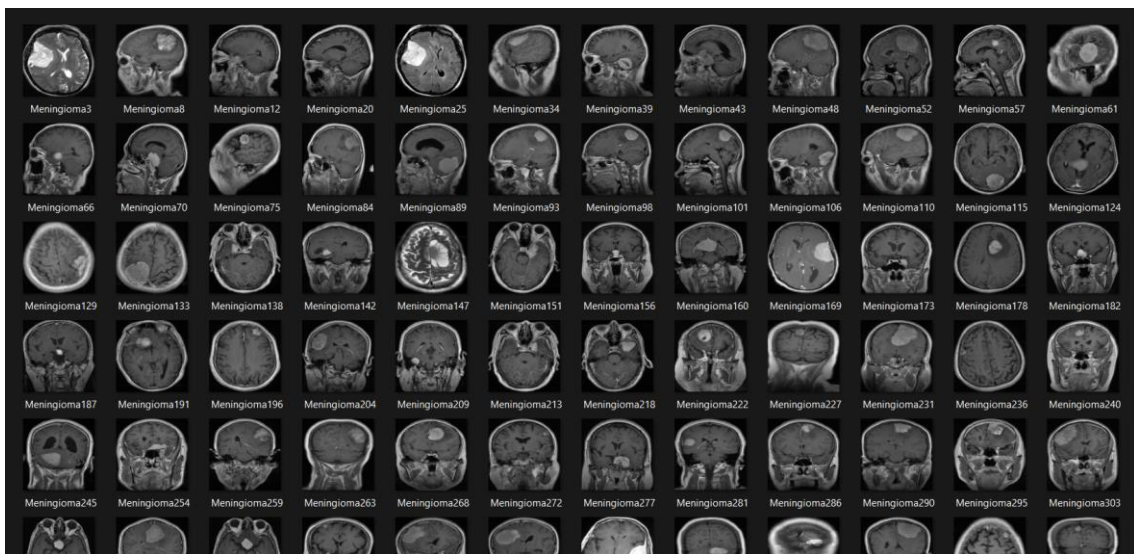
Meningioma Brain MRI
